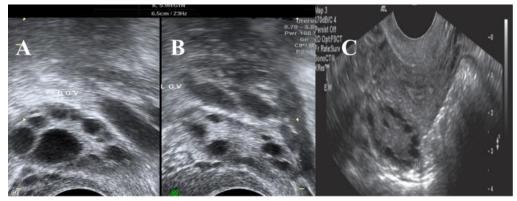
The numerous tiny necklace-like follicles occurring in both ovaries were discovered by ultrasound in patients with polycystic ovarian syndrome (A, B, C) [7].
